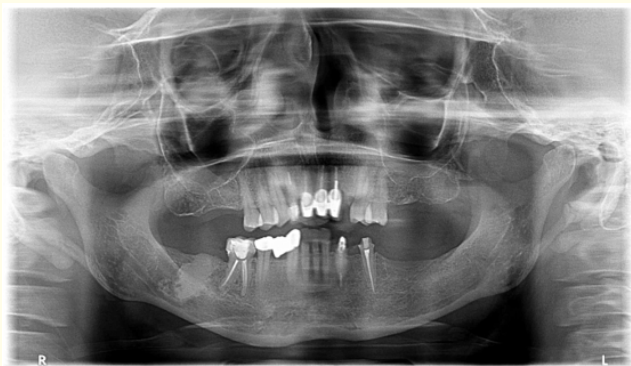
Orthopantomogram photograph showing unilocular radiopaque lesion at the right mandibular body region which extends from the alveolar ridge till the mandibular inferior alveolar canal.
